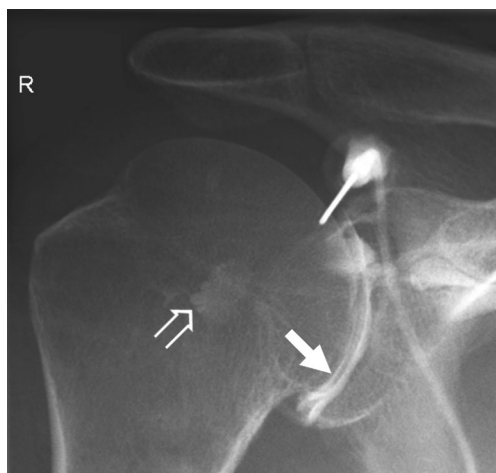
A 54-year-old man with partial articular-sided supraspinatus tendon avulsion (PASTA) lesion underwent glenohumeral infiltration. Radiograph shows the contrast agent distribution within the glenohumeral joint space (bold white arrow) and the posterior joint recess (open white arrow)
